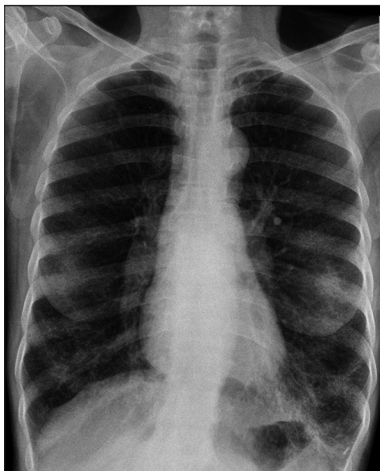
X-ray chest posteroanterior showing hyperinflation and reticular shadows bilaterally
